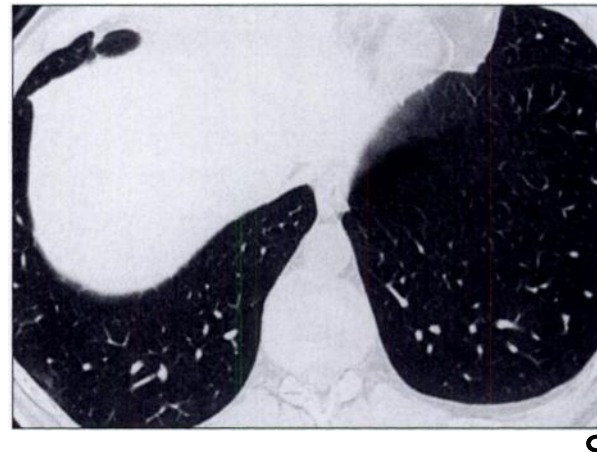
23-year-old man with pulmonary eosinophilic granuloma. A–C, High-resolution CT scans (1-mm collimation) of lungs at level of carina (A), base of heart (B), and lung base (C) reveal multiple thin-walled cystic structures involving lungs, with sparing of lung bases. In A, many cysts are confluent and superficially resemble emphysema. Note, however, presence of discrete cyst walls and eccentric location of vascular structures. No lung parenchymal nodules are visible. Note similarity of cyst morphology to lymphangiomyomatosis in B.
